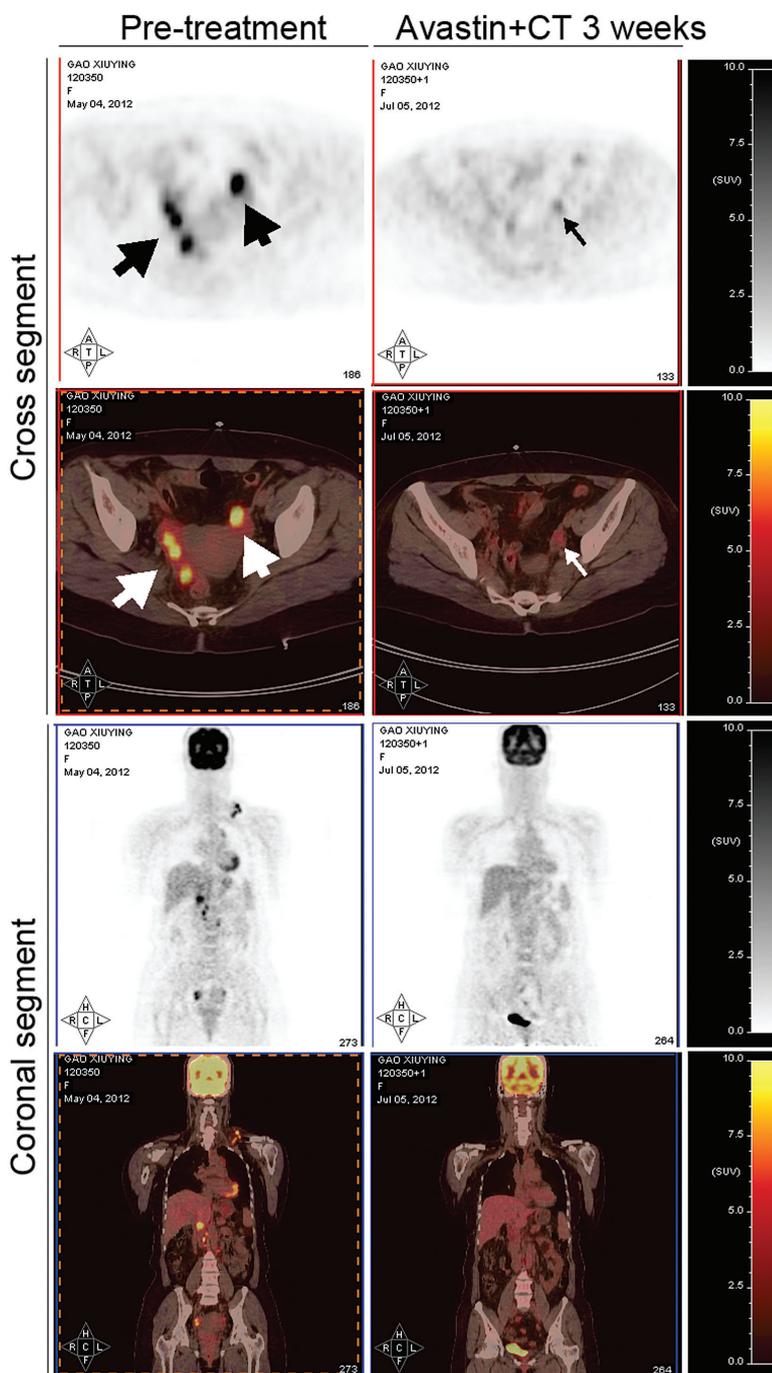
PET-CT views of pre-treatment and avastin plus chemotherapy treatment at three weeks.
